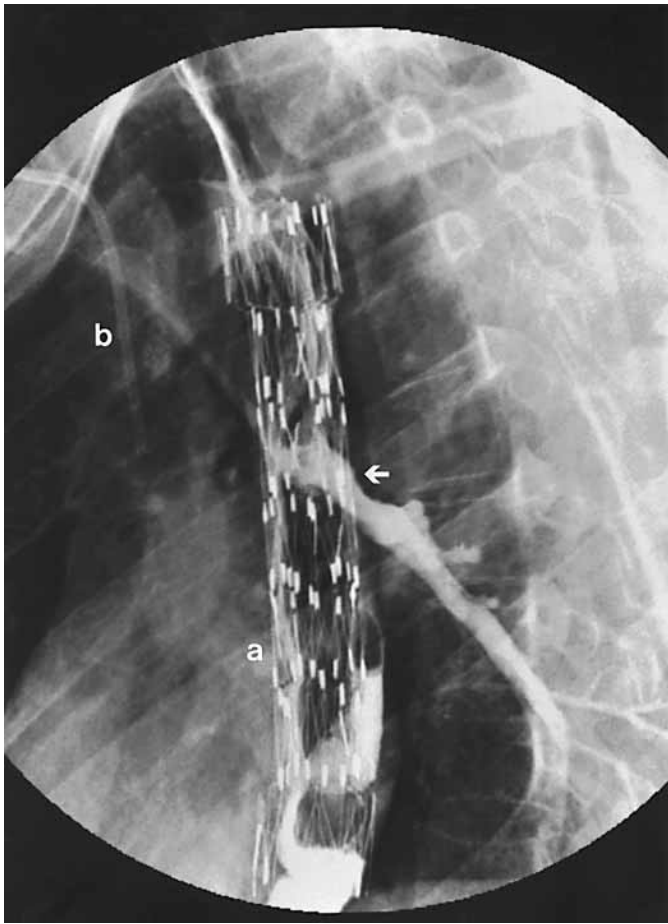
Gianturco-Song stents in lateral thorax X-ray (a). Contrast medium enters the bronchial system (arrow). Central venous port (b).
